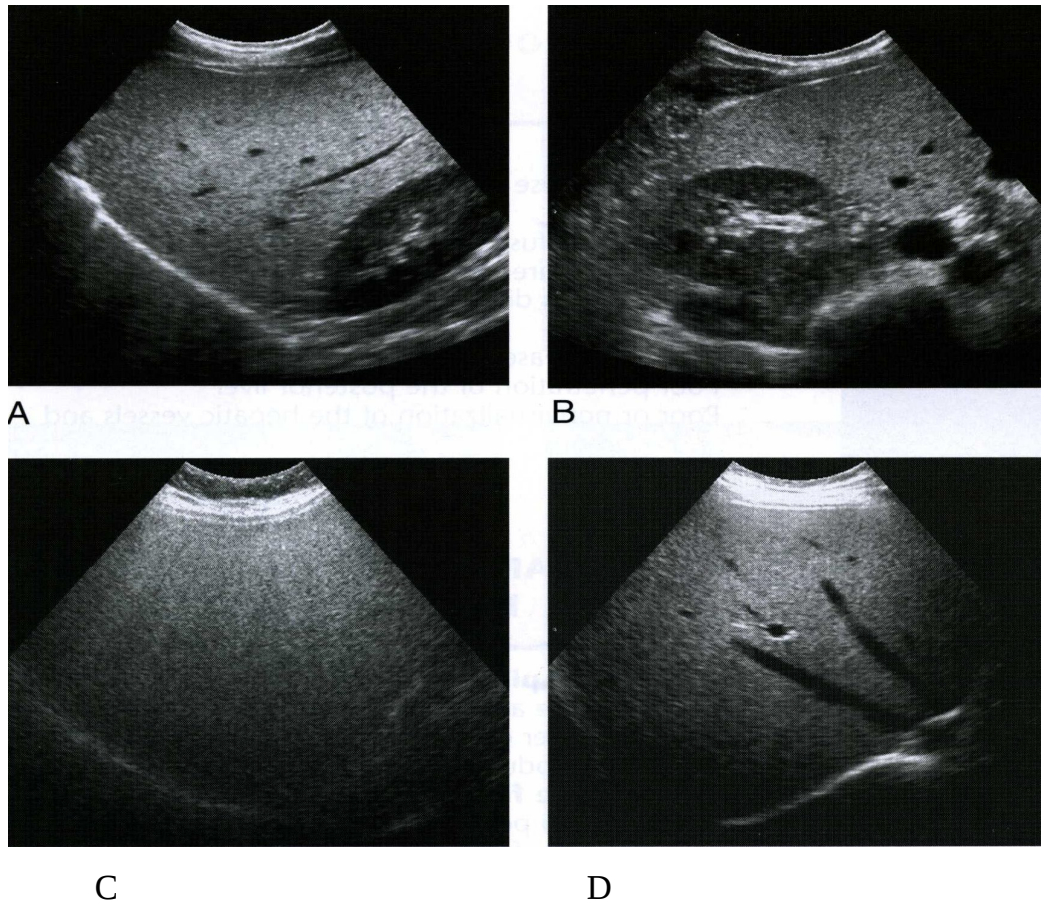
A,B,C&D showing ultrasound images of diffuse fat–spectrum of appearance (Rumak et, al 2005)
